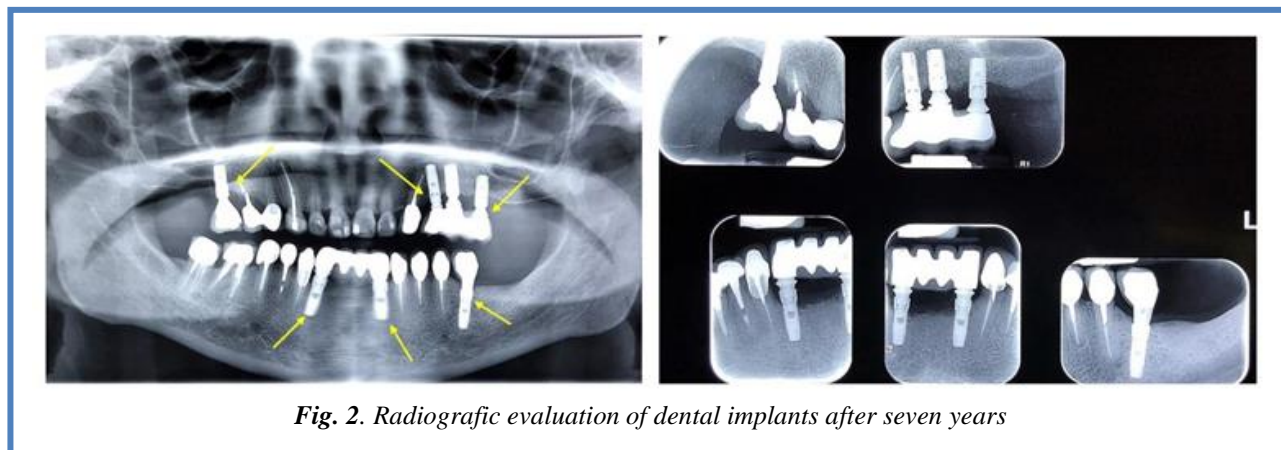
Radiographic evaluation of dental implants after seven years
